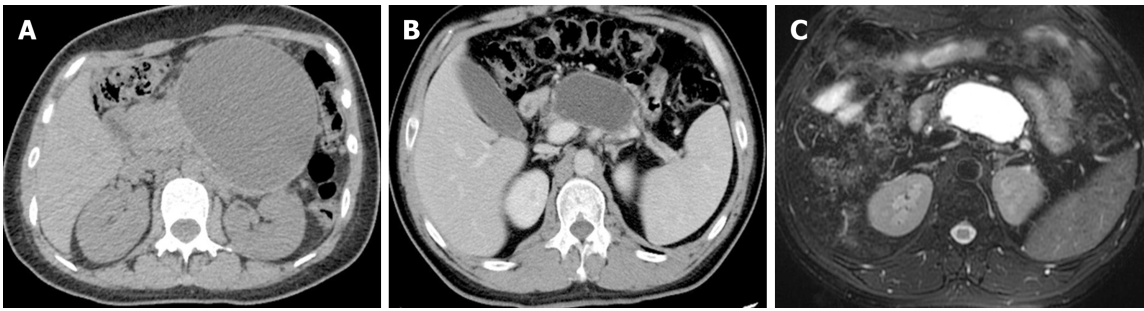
Perioperative images. A: Perioperative computed tomography (CT) angiogram of the female patient; B and C: Perioperative magnetic resonance cholangiopancreatography and CT images of the male patient.
